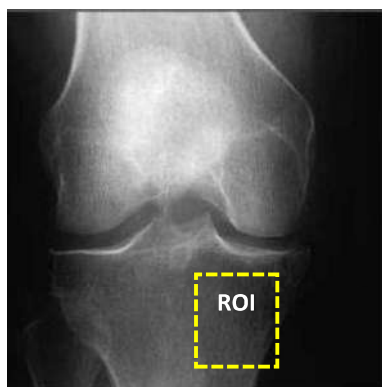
Knee radiographic image from [16]
